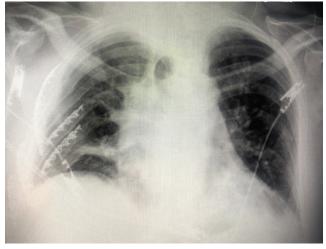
Postoperative chest radiograph demonstrating realignment of previously displaced fractures and hardware placement
